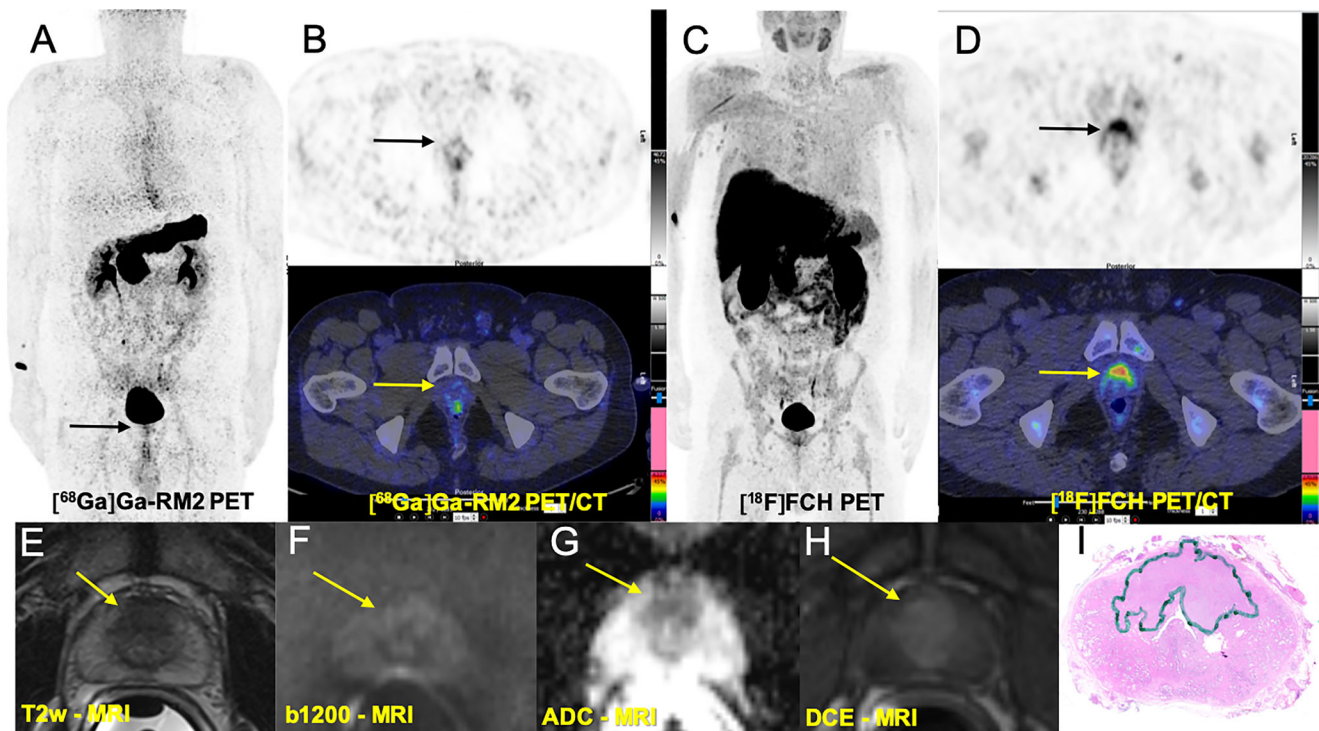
Comparison of [^{68}Ga]Ga-RM2 PET-CT with [^{18}F]FCH PET-CT and mpMRI in pre-operative staging of a prostate cancer patient with high risk of extraglandular metastases (PSA: 21.6 ng/ml, Gleason score: 7 (4 + 3), pT3a pN0 pR1 L0 V0 pn1. A [^{68}Ga]Ga-RM2 PET: maximum intensity projection. B Axial view [^{68}Ga]Ga-RM2 PET-CT (PET: upper, fusion PET-CT: lower row) from the prostate region shows no remarkable tracer uptake on the (arrows) (false negative). D [^{18}F]FCH PET-CT MIP. E Axial view [^{18}F]FCH PET-CT (PET: upper, fusion PET-CT:
